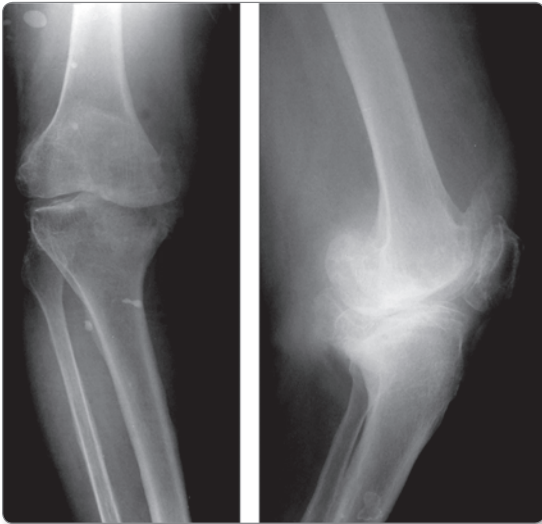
AP and lateral view X-rays showing large posterior defect
